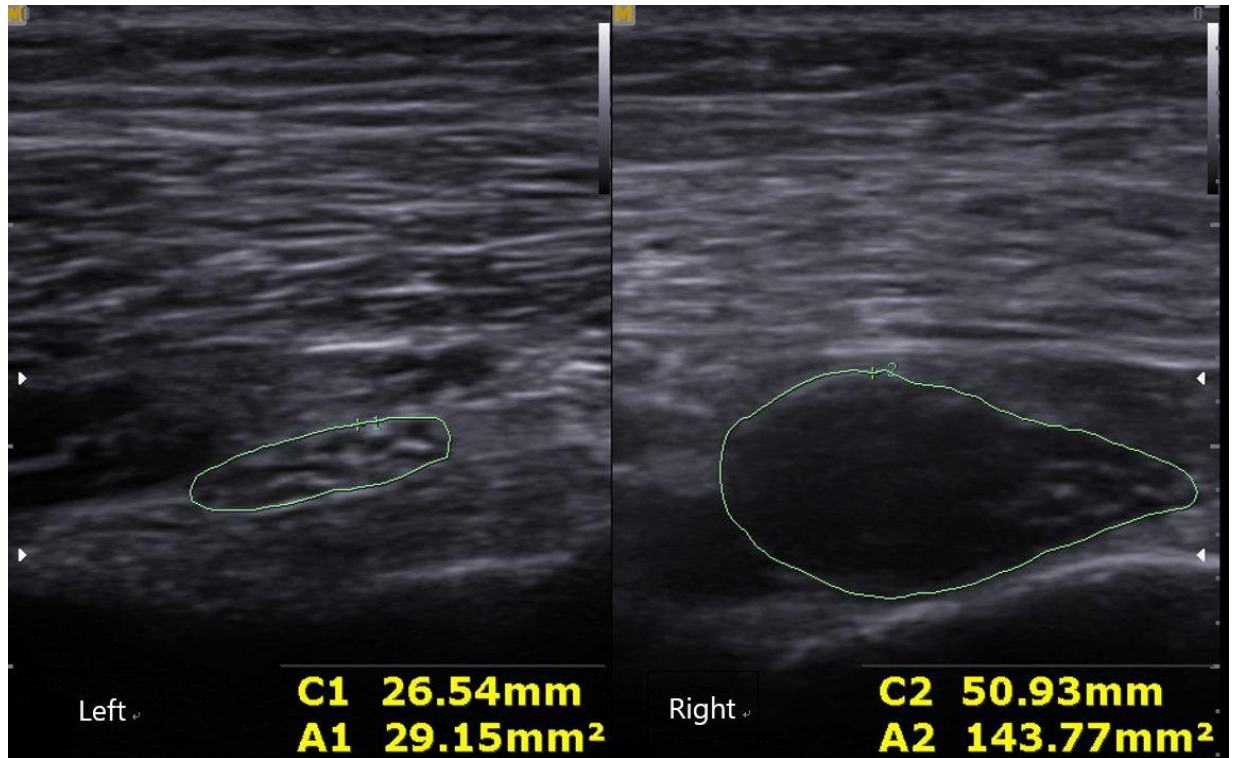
Cross-sectional sonographic image in mid gluteal area. The area of sciatic nerve is significantly increased on the right side compared to the left side.(C1/C2: Circumference of the left/right sciatic nerve, A1/A2: Area of the left/right sciatic nerve)
